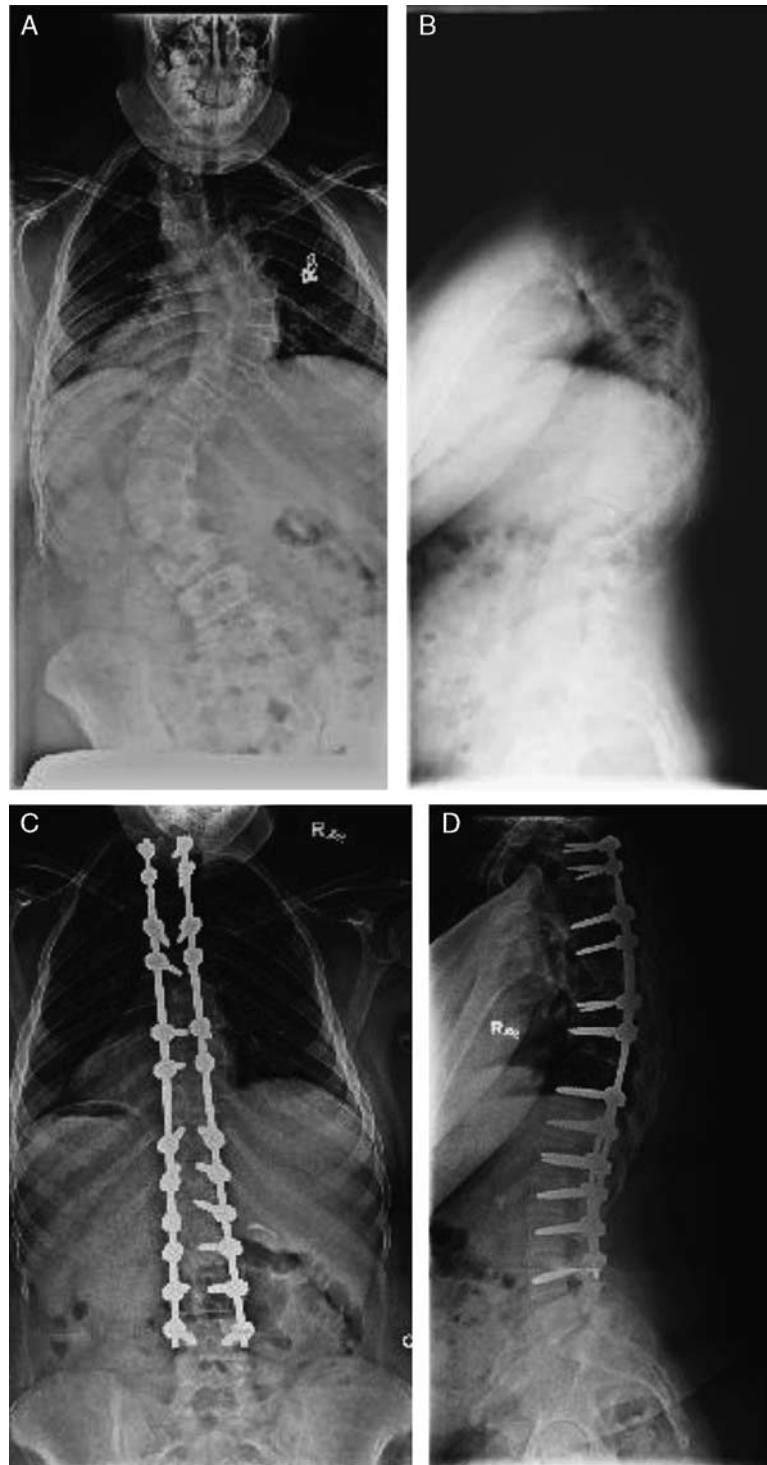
This 13-year-old girl with adolescent idiopathic scoliosis and a 75-degree right thoracic curve, as well as a 72-degree left lumbar curve, underwent posterior spinal fusion and had loss and return of motor evoked potentials twice intraoperatively. Somatosensory evoked potentials were unable to be monitored at baseline. Despite return of motor evoked potentials, the patient was found to have weakness and sensory changes on the evening of postoperative day 0, which resolved with dopamine-induced pressure elevation in the pediatric intensive care unit for 2 days after surgery and therefore were thought to be secondary to cord ischemia. A, Preoperative anteroposterior radiograph. B, Preoperative lateral radiograph. C, Postoperative anteroposterior radiograph. D, Postoperative lateral radiograph.
